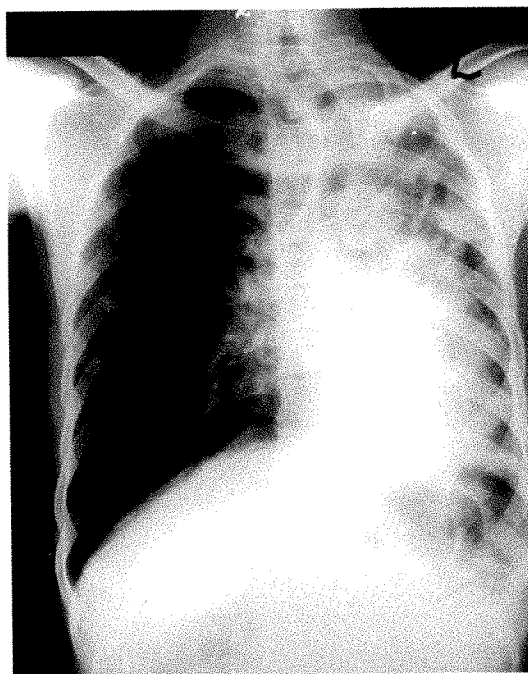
Postero-anterior chest radiograph which demonstrates severely diseased left lung and mediastinal displacement.
